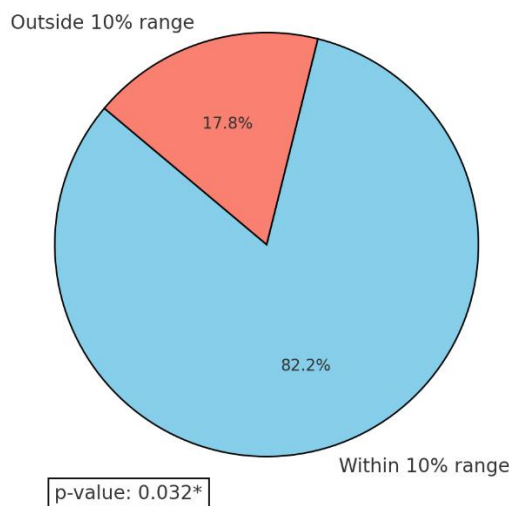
Accuracy of sonographic estimation within 10% of actual birth weight
